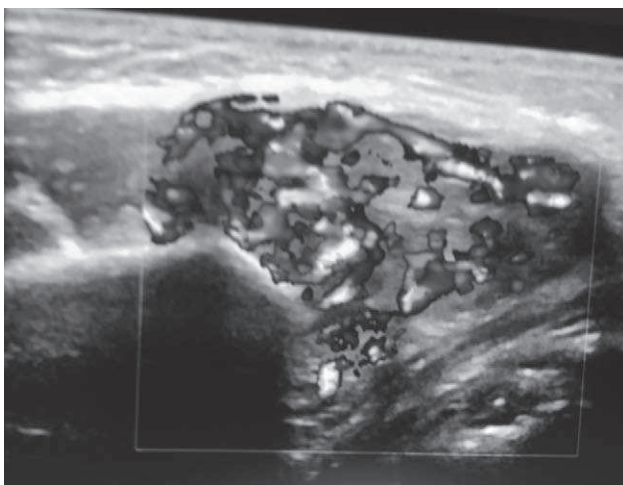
The ultrasound images demonstrate a fusiform heterogeneously hypoechoic highly vascularized lesion within the muscle with cystic areas representing blood-filled cavities. No calcification seen within the lesion.
